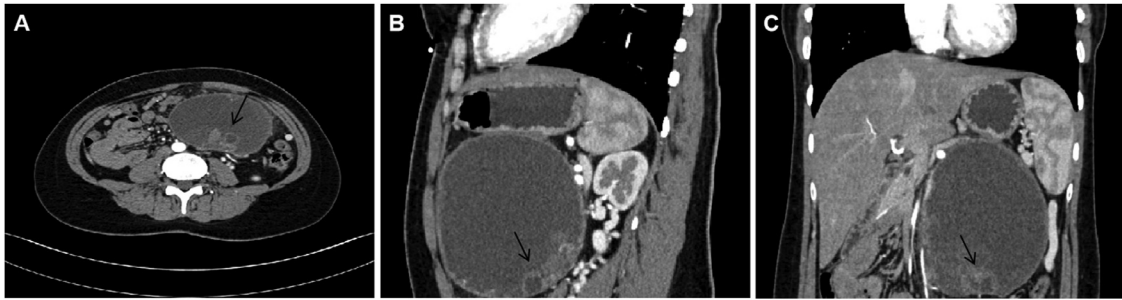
(A) Axial, (B) sagittal, and (C) coronal abdominal contrast-enhanced CT scan demonstrating a large pancreatic solid-cystic mass, there were multiple nodules in the capsule, the shape was irregular, and the density in some nodules was uneven (indicated by arrows).
